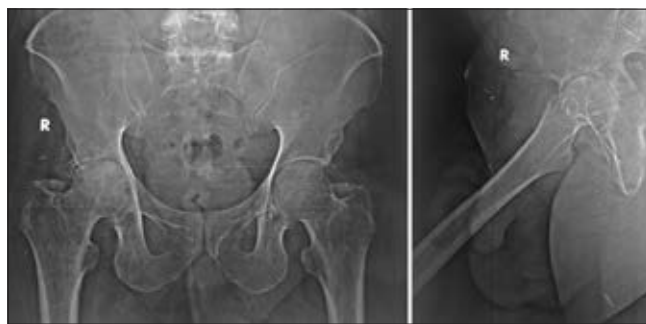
Radiograph of the right hip anteroposterior and cross table lateral view showing concentric joint space reduction and marginal osteophytes. Subchondral cysts and subchondral fracture can be seen in weight bearing area
